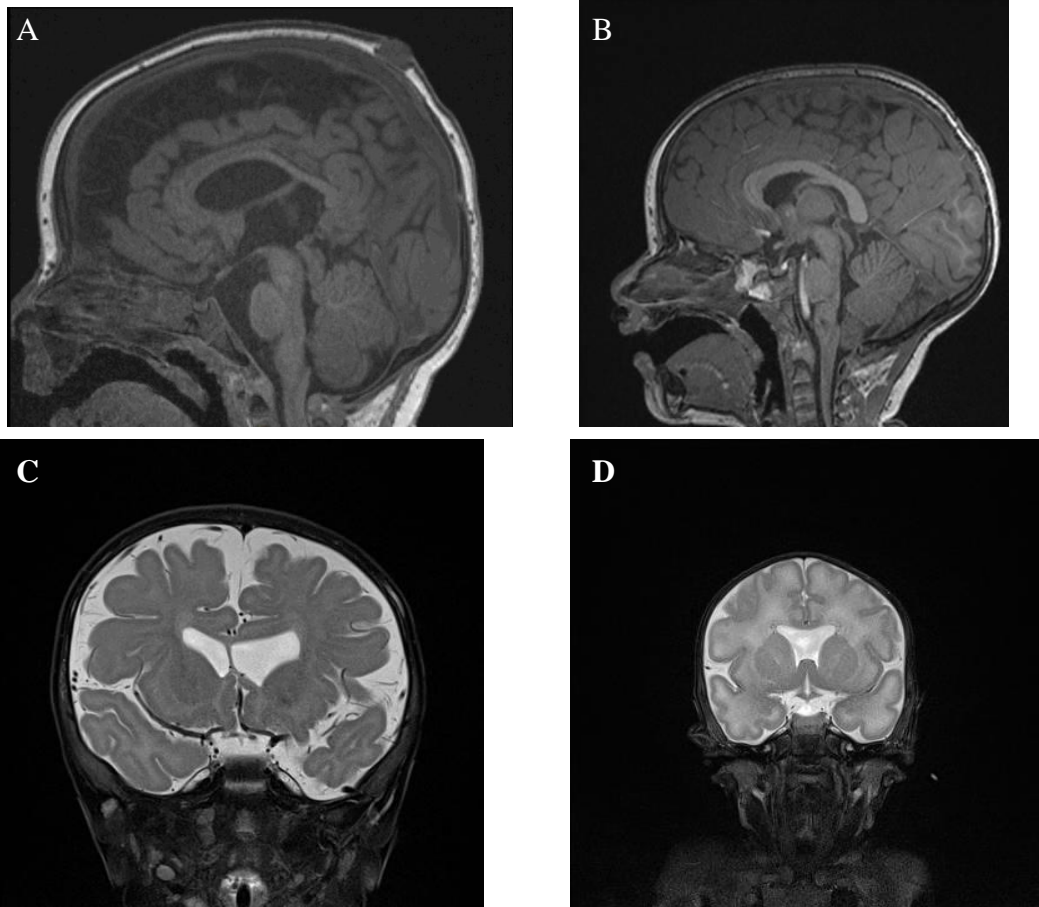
Brain and Pituitary MRI
